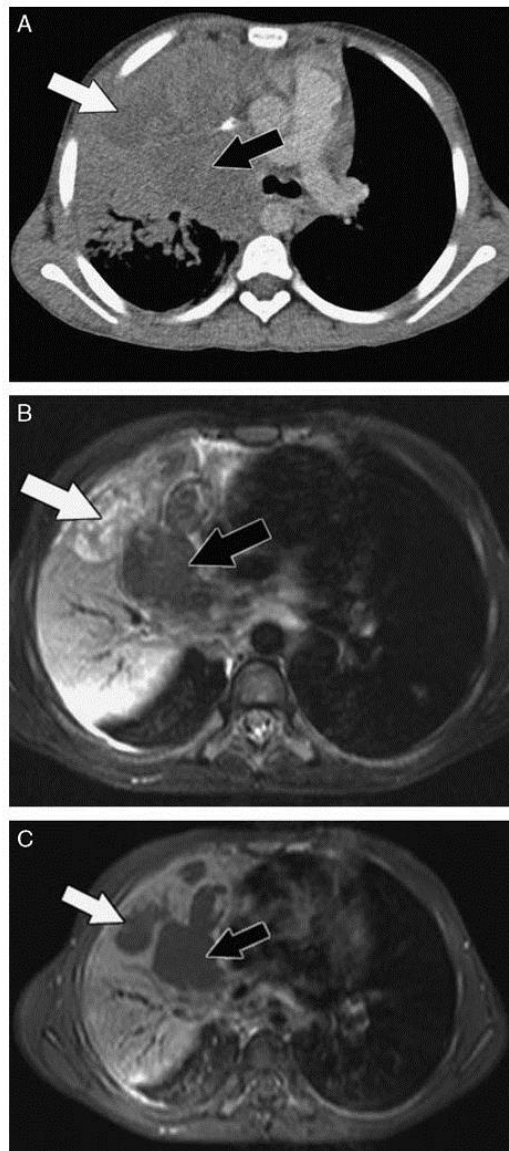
Axial images demonstrating lung necrosis on CT scanning and corresponding varying signal on MRI. A, Postcontrast CT scan of the lungs demonstrating central areas of low density (arrows) within an area of airspace consolidation. Note the lack of vessels, bronchograms, and enhancement in the areas of low density, representing lung necrosis. In contrast, the airspace consolidation demonstrates enhancement, vessels, and air bronchograms. B, STIR MRI demonstrates that one area of CT low density demonstrates high signal (white arrow) intensity, whereas the other demonstrates low signal intensity (black arrow) presumably due to different stages of necrosis. C, Postgadolinium T1-weighted MRI demonstrates that the areas of CT low density lack enhancement (arrows), whereas the airspace consolidation enhances.
